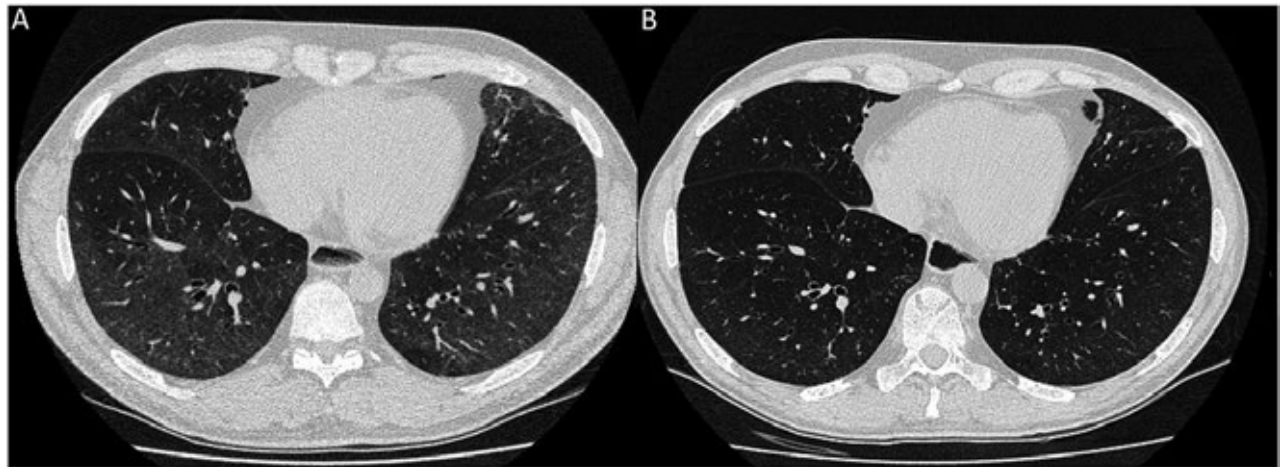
Axial plane HRCT scan above the level of the diaphragm showing marked reduction of ILD extension in a 45-year old man treated with HSCT. Fig. A: 4 months before HSCT; Fig. B: 13 months after HSCT.
